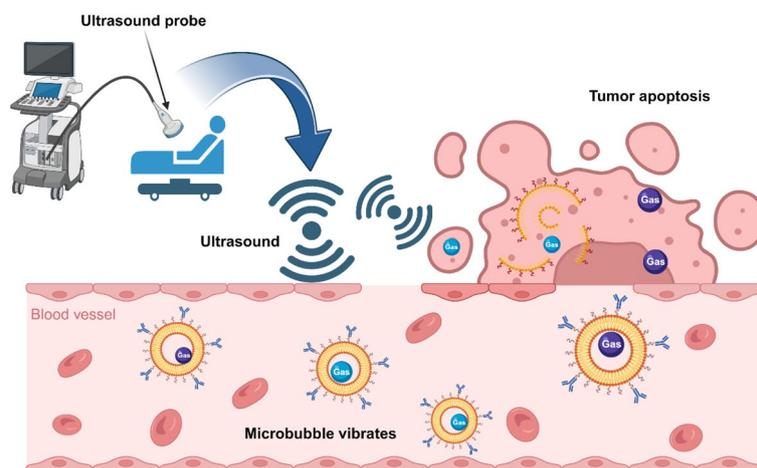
Combination of liposome with gas as a therapy for cancer. Under ultrasound, the liposomes precisely target tumor cells through the induction of microbubble vibrates in blood vessels. At the tumor target site, the gas released from liposomes interacts with the tumor cells and promotes apoptosis. (Reused with permission from (Chen et al. 2024). Creative Commons CC-BY license)
